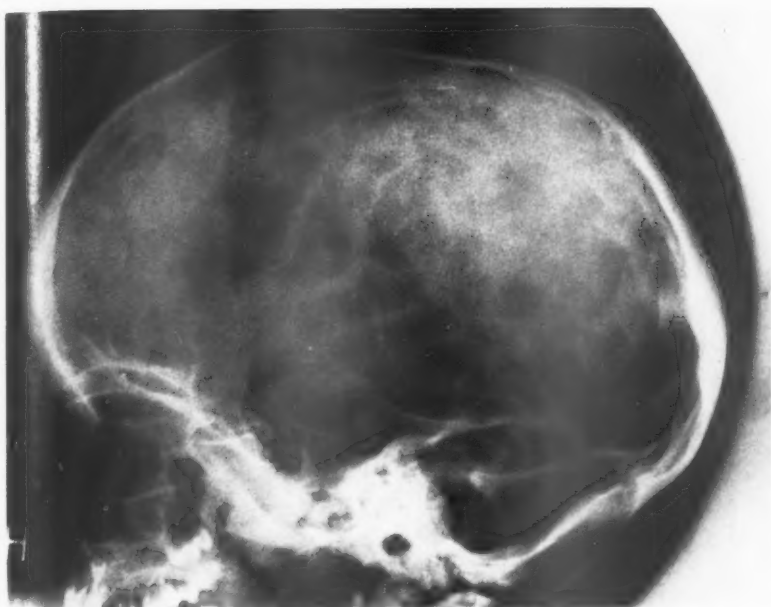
A. Roentgenogram of the skull of the patient E. S. 19.4.48 sagittal projection showing premature closure of the sutures, increased impressions, and a prominence corresponding to the region of the large fontanelle.
